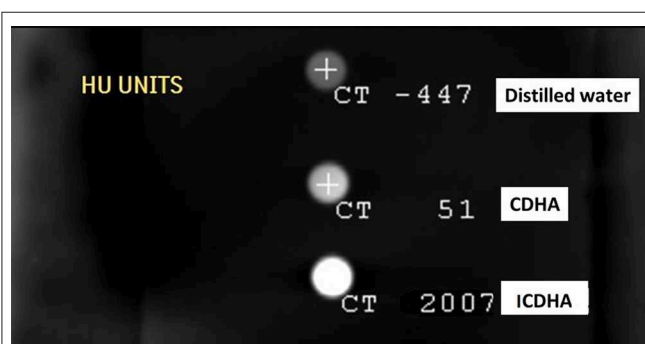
CT contrast of ICDHA samples compared with CDHA in HU (Hounsfield Units).
